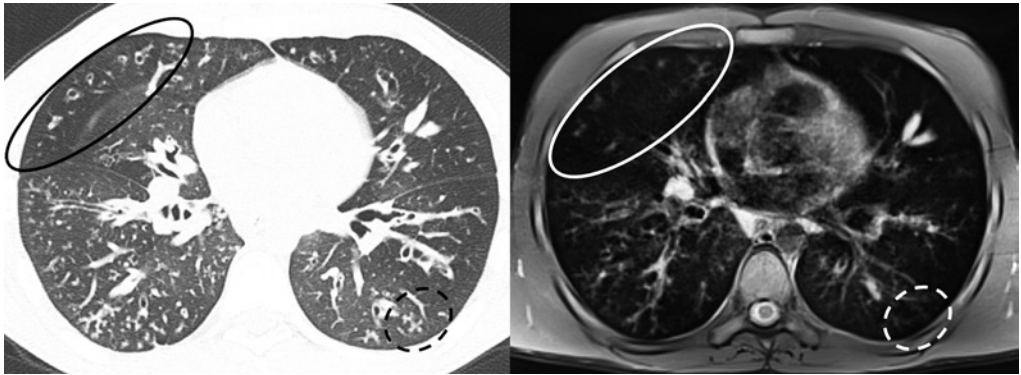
Example of underestimation by chest MRI relative to chest CT. On the left the CT image during inspiration and on the right the correspondent PROPELLER MRI image. Note the peripheral bronchiectasis depicted by CT in right upper lobe tend to disappear in the correspondent MRI image (white dotted ovals). Similarly the small areas of tree-in bud in the left lower lobe are blurred and therefore less visible in the correspondent MRI image.
